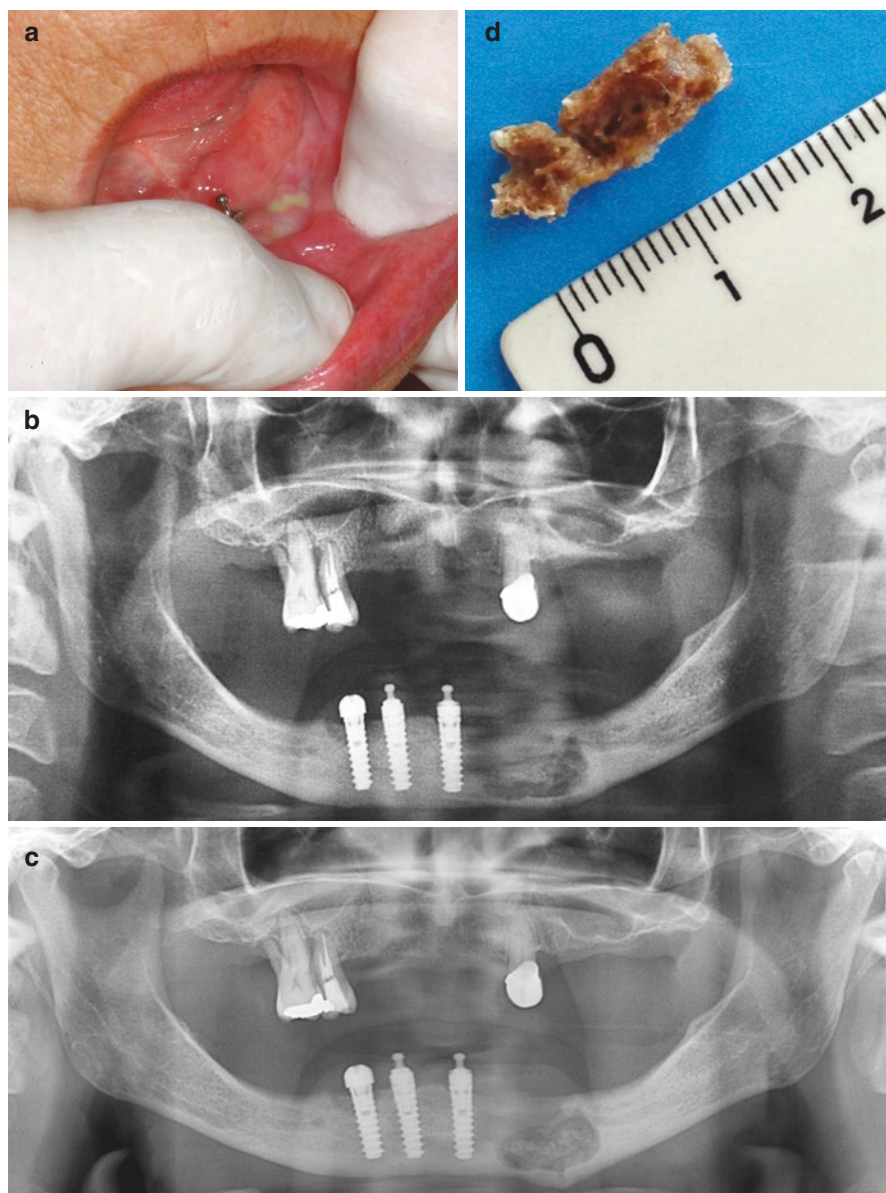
(a) Infection with intraoral drainage after loss of implant in patient using oral bisphosphonates for treatment of osteoporosis. (b) Area of osteonecrosis in anterior mandible. Local and systemic conservative treatment was instituted. (c) Bone remodeling adjacent to implant. Bone sequester still present in the mandible. (d) Extruded bone sequester. (e) Radiograph after resolution of infection
